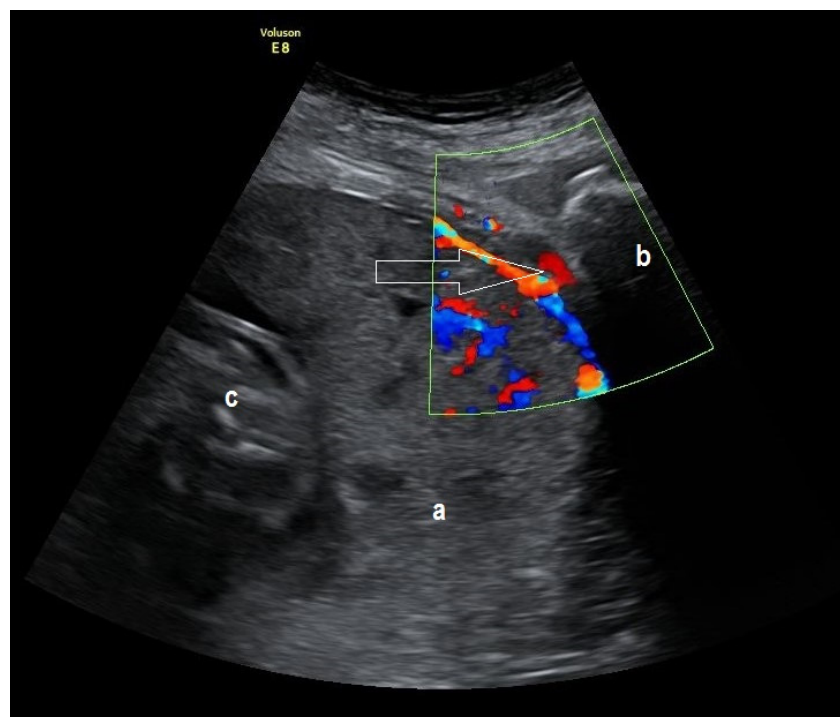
Ultrasound examination showed features of placenta infiltrating the bladder base (arrow): thin retroplacental myometrial, irregularity of the uterine-bladder interface, and presence of blood flow on the bladder; a – placenta, b – bladder, c – foetus
